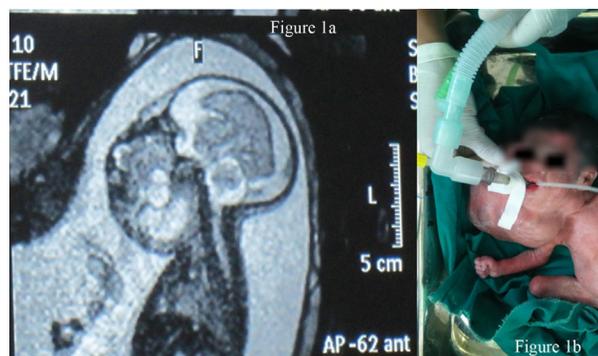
a : Magnetic Resonance Image of the fetus at 27 weeks of pregnancy. b. : Baby with supraglottic airway (SGA) in situ.
